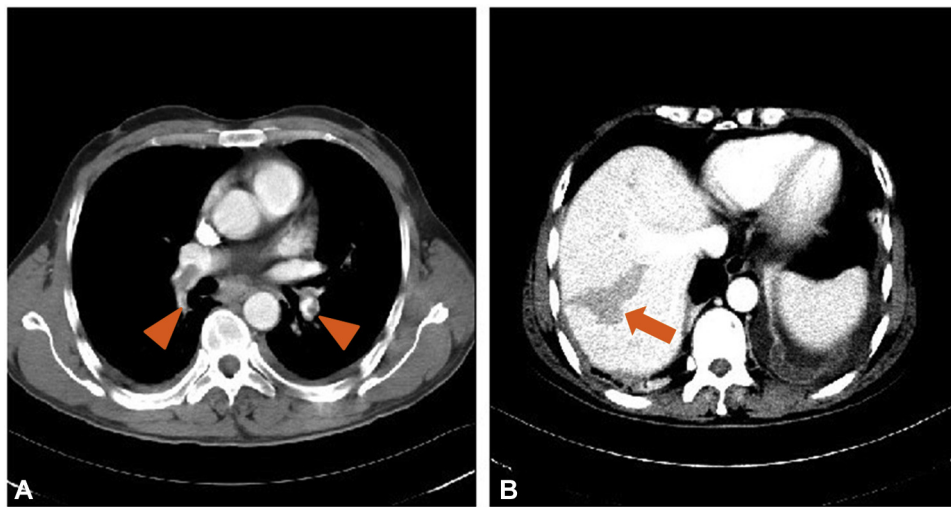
CT scan of chest and abdomen. A, Pulmonary embolism (*arrowheads*) and B, liver embolism (*arrows*).
